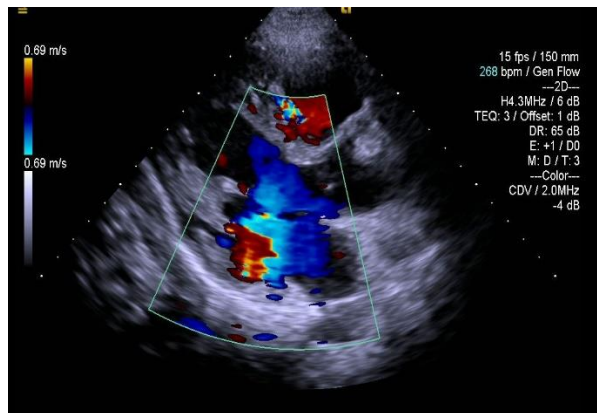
The parasternal short-axis view on 2D echocardiography with color flow mapping demonstrates coronary collateral vessels supplying myocardial perfusion.
